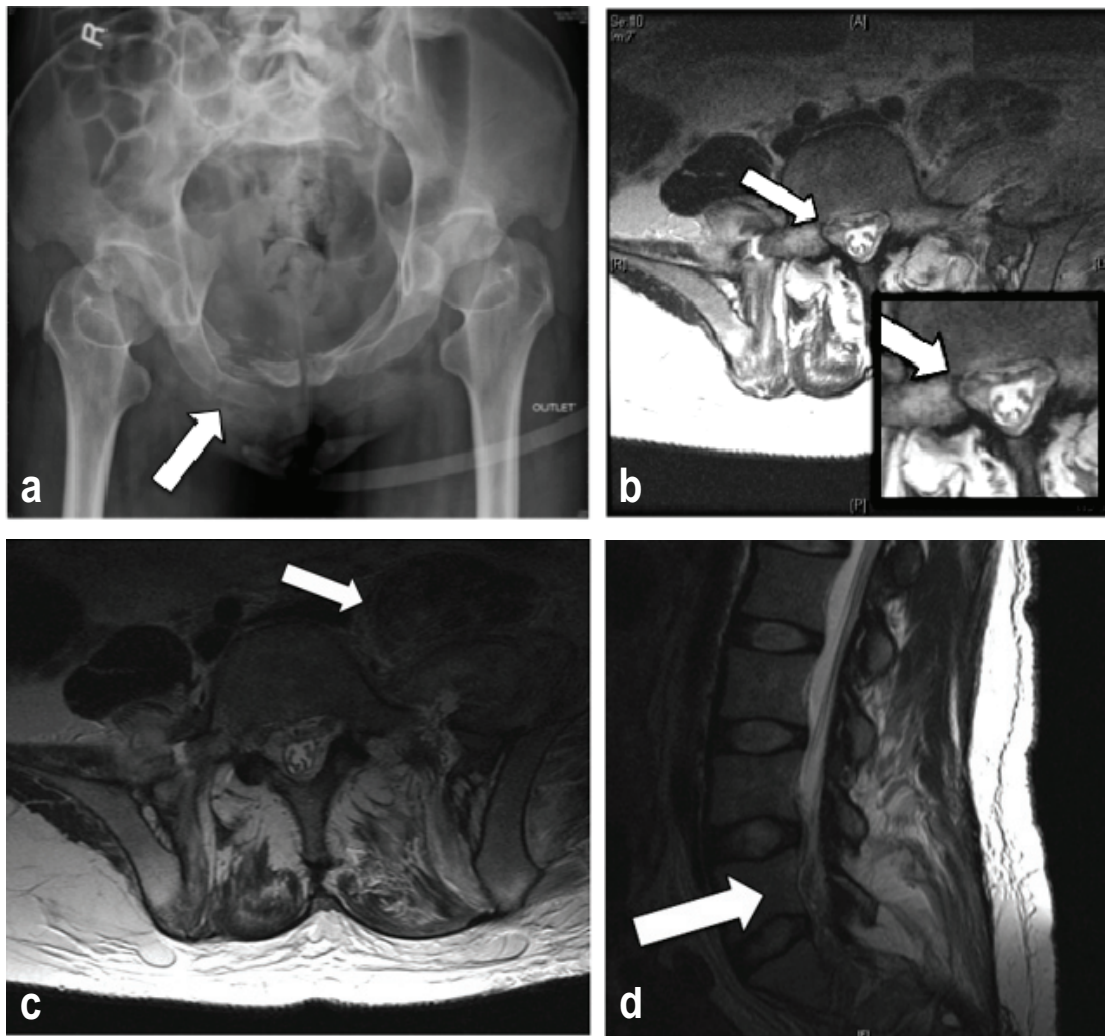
a) an anteroposterior X-ray outlet view of the patient's pelvis showing multiple fractures of the superior and inferior pubic rami; b) axial T2-weighted non-enhanced magnetic resonance image plus magnification showing hematoma adjacent to the right L5 nerve root at the exit foramen (arrow); c) a more cranial axial view showing the extent of the pelvic hematoma, and d) a sagittal view at the right exit foramina showing hematoma around the distal cauda equina.
